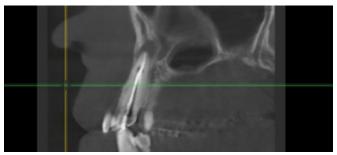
Inadequate canal obturation: root canal filling confining >2mm from the apex of the radiograph, or root canal filling extending over the apex, nonhomogeneous root canal filling, deficient condensation, and apparent vacuity.
